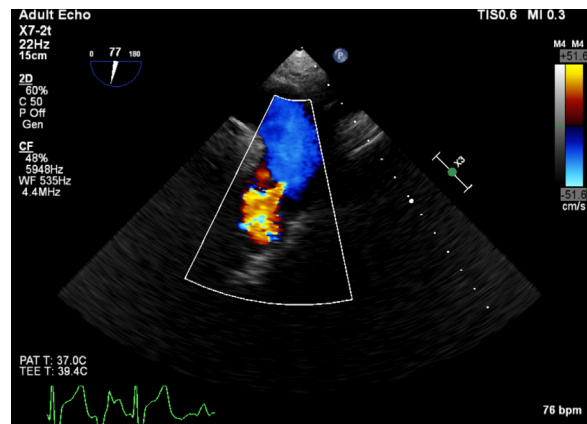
Color Doppler midesophageal ascending aortic short-axis transesophageal echocardiography image during late diastole.
